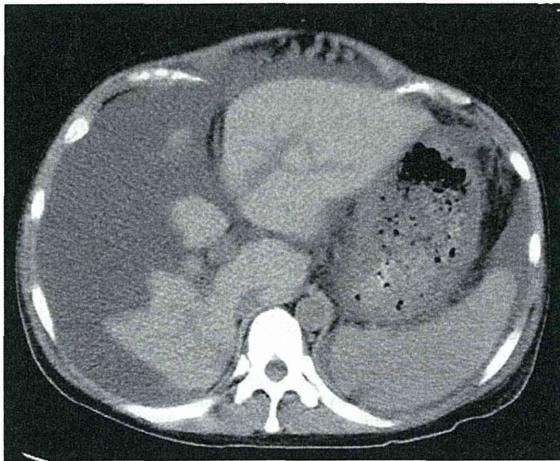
Computed tomography scan showing a large quantity of ascites and significant atrophy of the right lobe of the liver.
